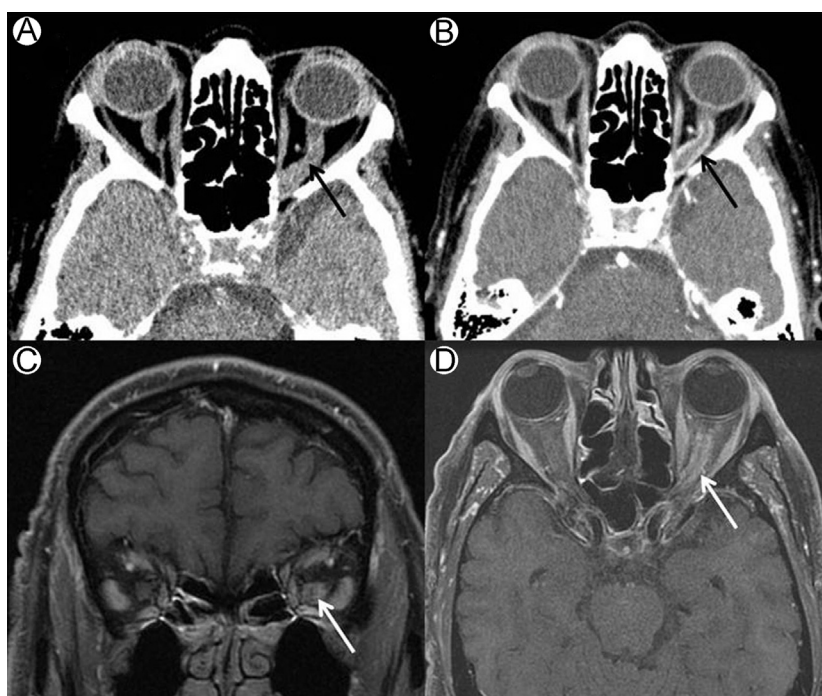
Left optic nerve sheath meningioma: (A) precontrast CT scan shows patchy high-density calcification (arrows) and (B) postcontrast CT shows tram-track enhancement (arrows) confirmed on the coronal and axial T1-fat-saturation postcontrast MRI (arrows, C and D). CT, computed tomography.
